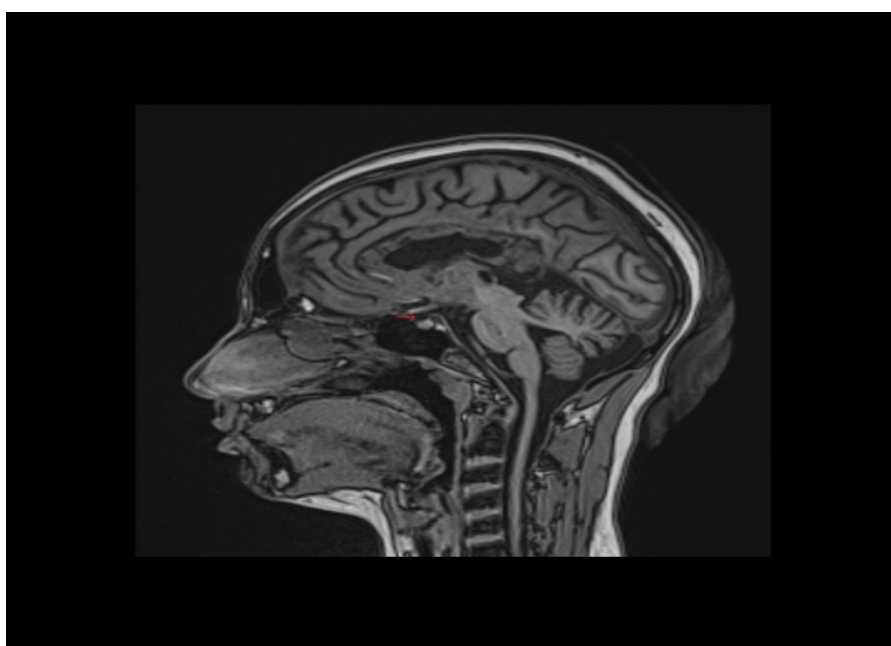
Figure 2: Sagittal T1 weighted MRI
